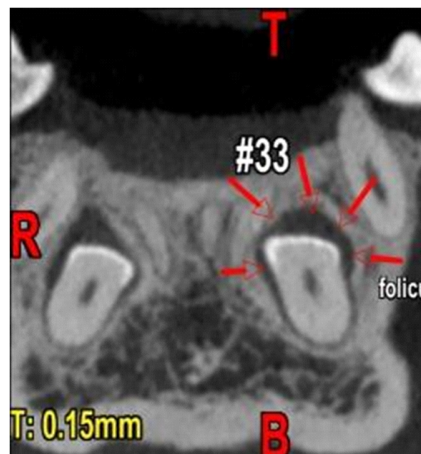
Coronal section of CBCT indicating impacted 33 and 43.
